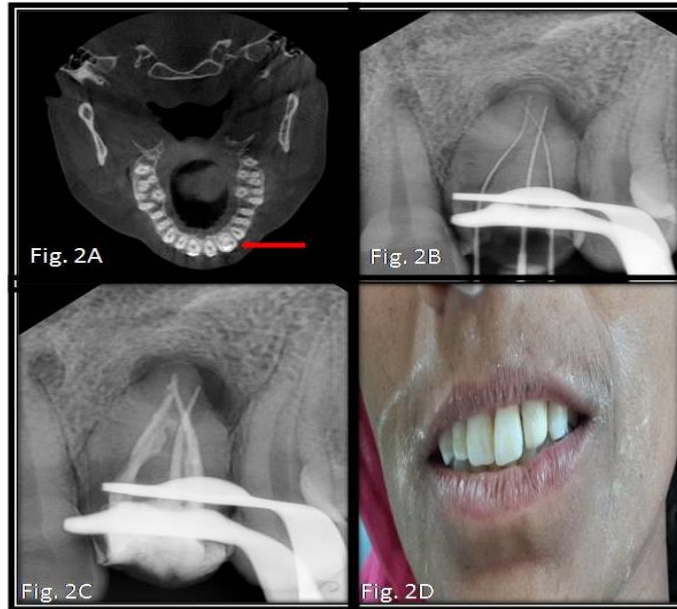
A Pre operative CBCT (Axial section). Note the three coronal orifices
